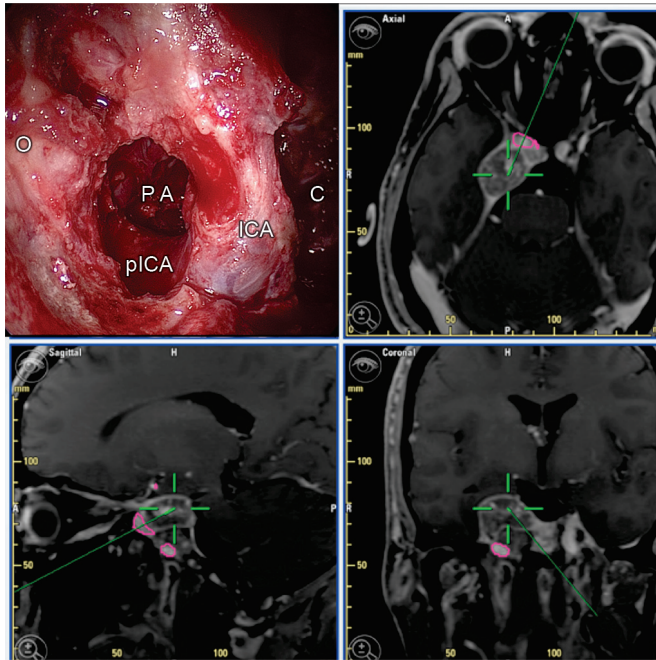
Intraoperative magnetic resonance imaging (MRI)-based image-guided tracking of the lesion (chordoma). The transpterygoid approach allows the tumor resection laterally to the internal carotid artery.
